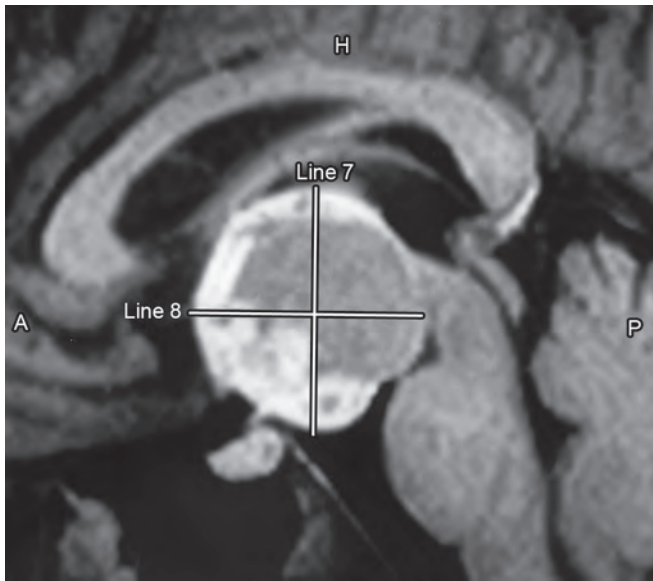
Magnetic resonance imaging showing a large heterogeneous craniopharyngioma on contrast administration
